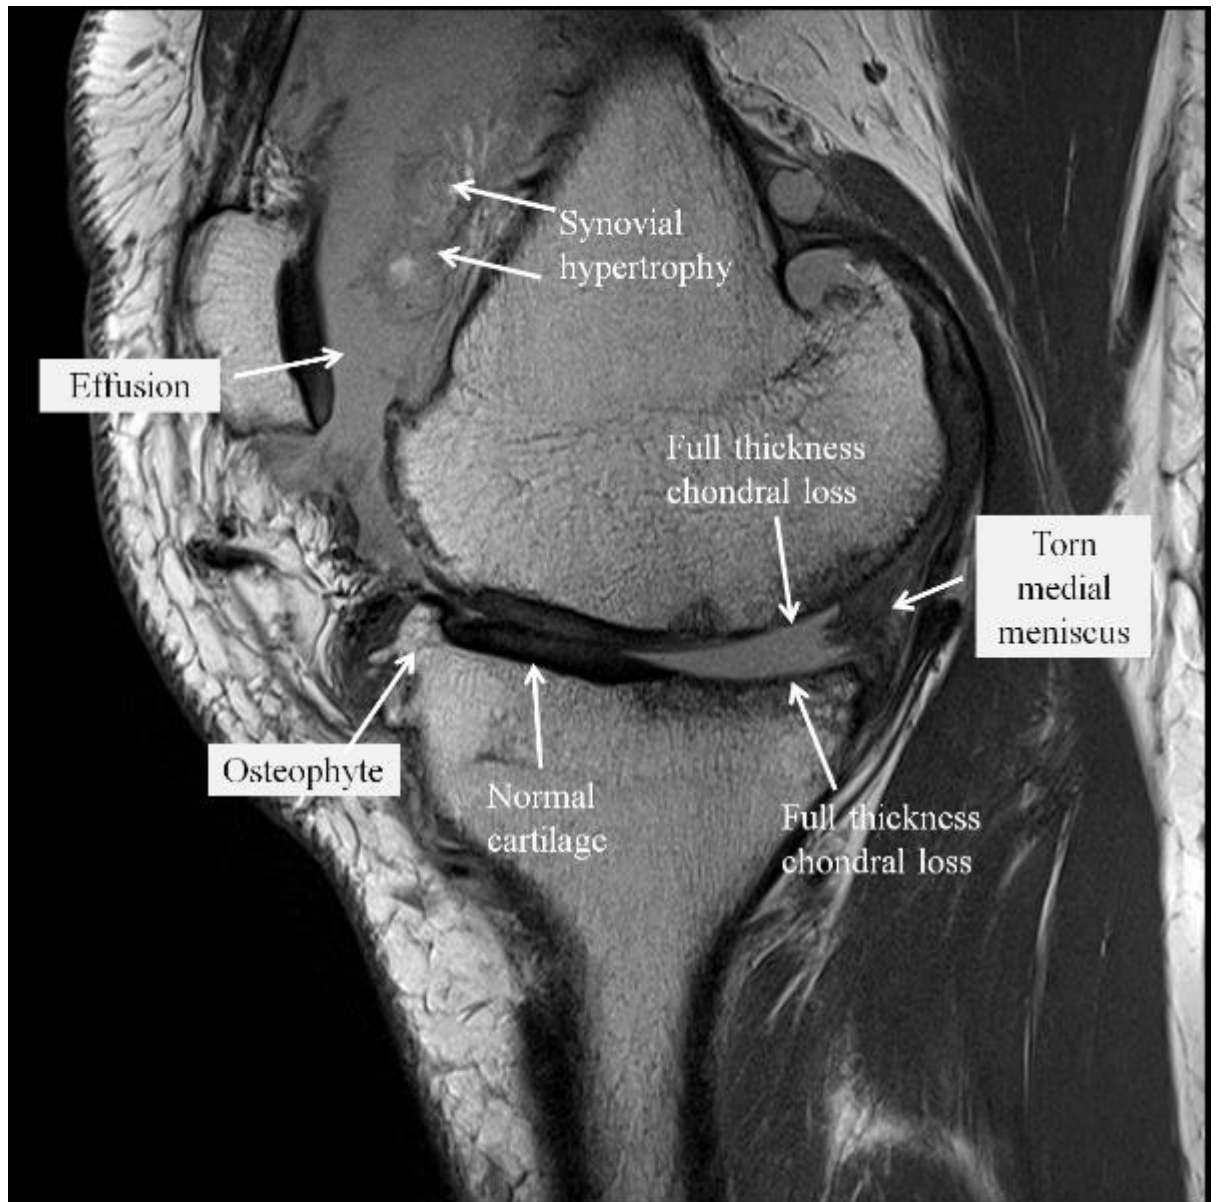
Sagittal proton density MRI showing advanced medial femorotibial compartment osteoarthritis, with full-thickness cartilage loss, large effusion and prominent synovial thickening. Note also the chronically torn medial meniscus and osteophyte formation.
